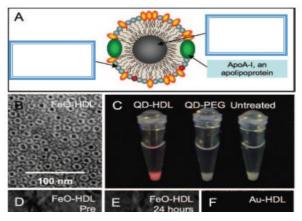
Particles in vitro in MRI atherosclerosis [8].
